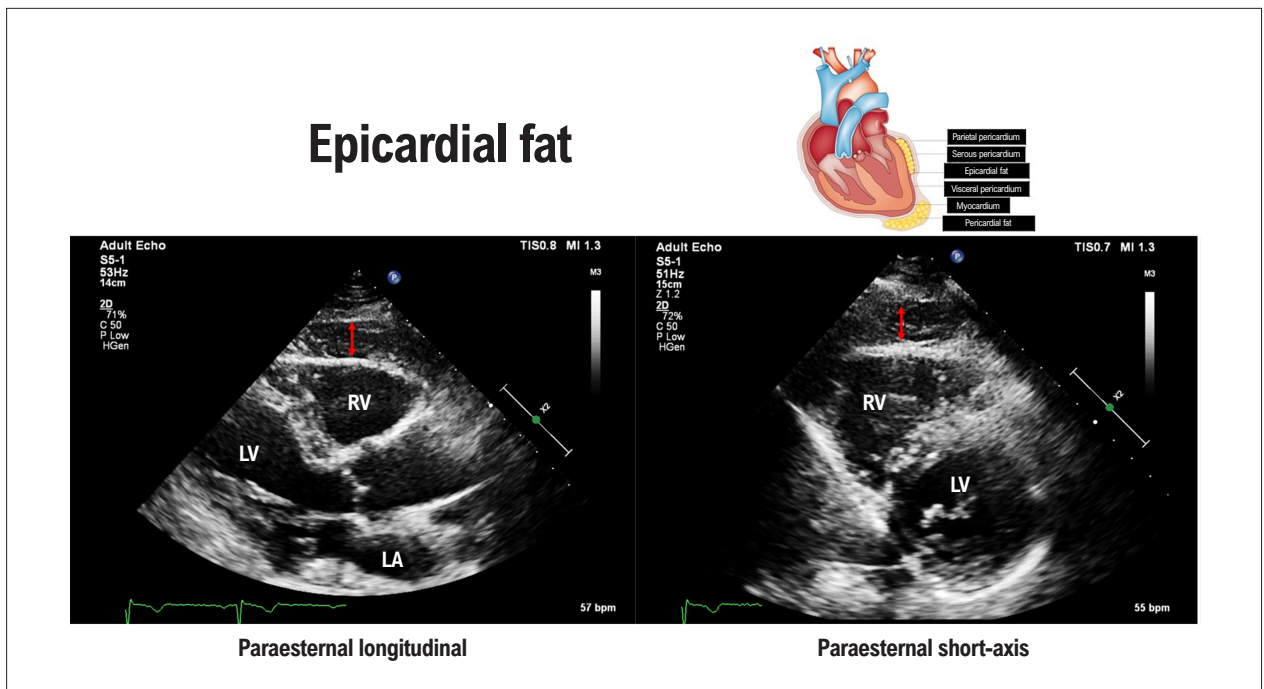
Echocardiographic images in the parasternal longitudinal and short-axis window of a patient with metabolic syndrome and extensive epicardial fat layer. Differential diagnosis with pericardial effusion is essential due to the difference in complementary investigation and clinical treatment. LA: left atrium; LV: left ventricle; RV: right ventricle.
